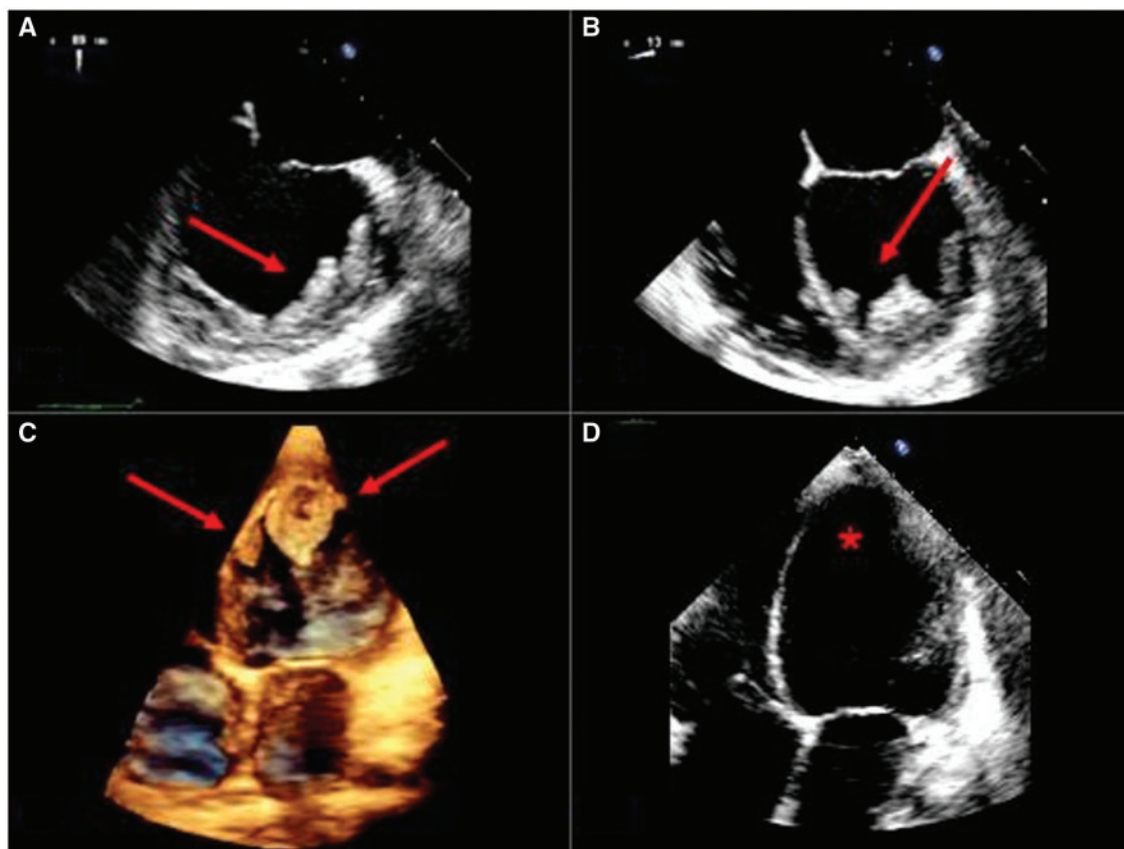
Trans-oesophageal (A, B) and transthoracic (C) echocardiographic images 1 week after starting unfractionated heparin showing changed masses. At discharge (D), disappearance of masses can be seen.
